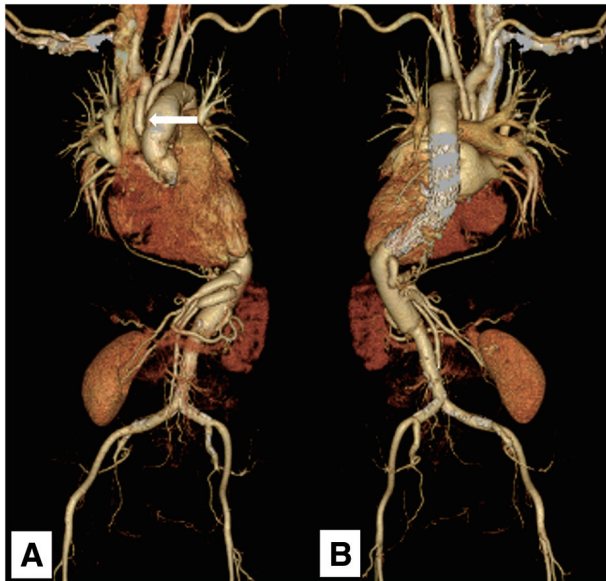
(A) In the anterior view, preoperative 3D CTA showed that flexion of the aorta and the angle between left common carotid artery (white arrow) and the aortic arch were very steep. (B) In the posterior view, an artificial vascular stent was placed in the thoracoabdominal aorta and a thoracoabdominal aortic aneurysm was also observed.
